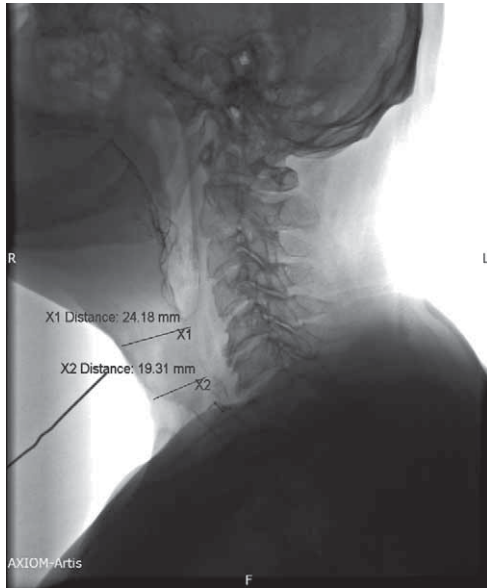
Lateral x-ray before lidocaine injected, measuring the spastic segment of the neo-larynx with radiopaque marker.
